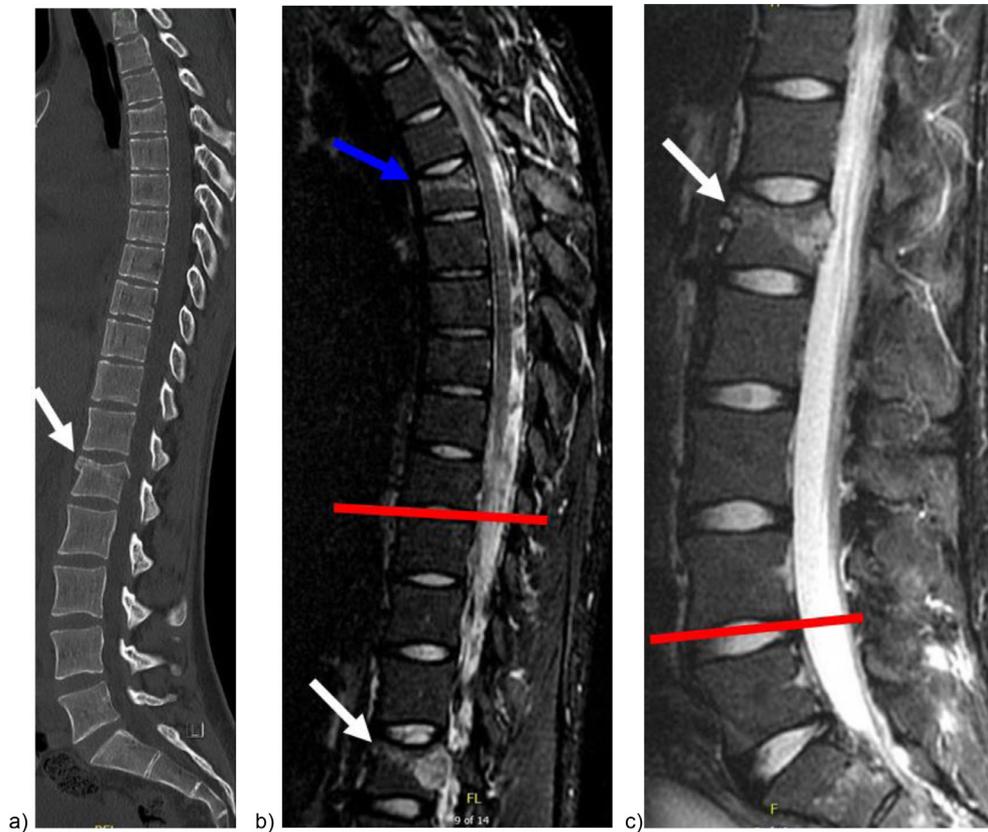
Sagittal CT (Left) demonstrates an incomplete burst fracture involving superior end plate at L1 (white arrow). Thoracic (Middle) and lumbar (Right) spine sagittal STIR MRI images demonstrate L1 fracture (white arrows). The proposed focused zone would be limited to T10 through L4 in this case, as demarcated by the red lines in b and c. Thoracic spine sagittal STIR MRI in b demonstrates increased signal at T4 consistent with an acute compression fracture (blue arrow) occurring in the distant zone (i.e. outside of the focused zone). This injury would be missed on a focused MRI.
